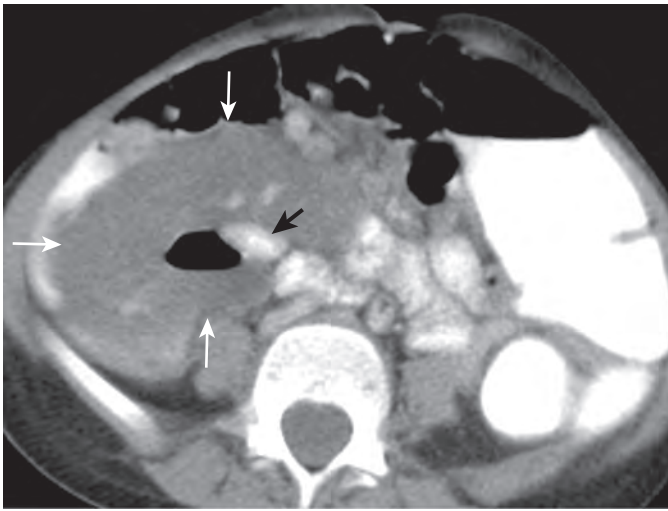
Plexiform neurofibroma. This CT scan in a 6-year-old boy with neurofibromatosis type 1 shows an elongated soft tissue mass in the right lower quadrant (white arrows) contiguous with multiple segments of small bowel (black arrow). Surgical pathology confirmed infiltration of the small bowel wall into the intermyenteric plexus.
